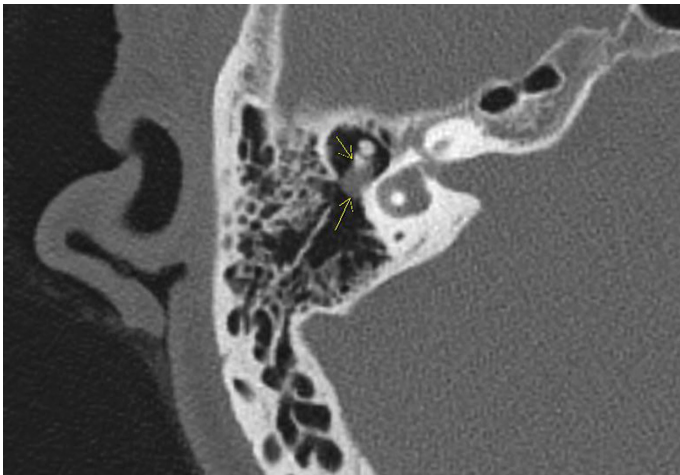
Preoperative computed tomography showed a round, high soft tissue density mass in the mastoid antrum that was in contact with the short process of the incus.
